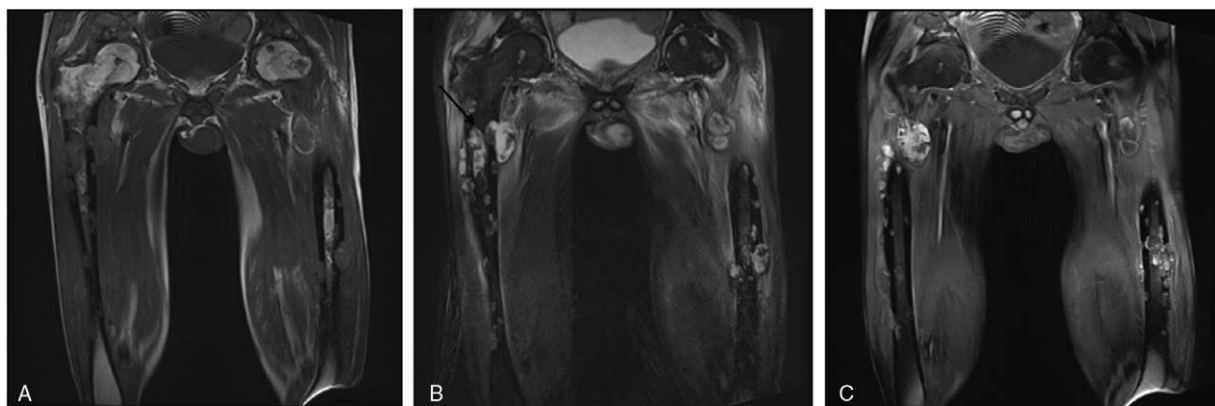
MRI of bilateral thighs showed irregular lesions with intermediate intensity on T1-weighted imaging (A) and a high- and low-signal intensity rim (dark arrow) on fat-suppression T2-weighted imaging (B). Annular enhancement was observed on enhanced scanning (C). The bone cortex was destroyed, with soft-tissue involvement.
